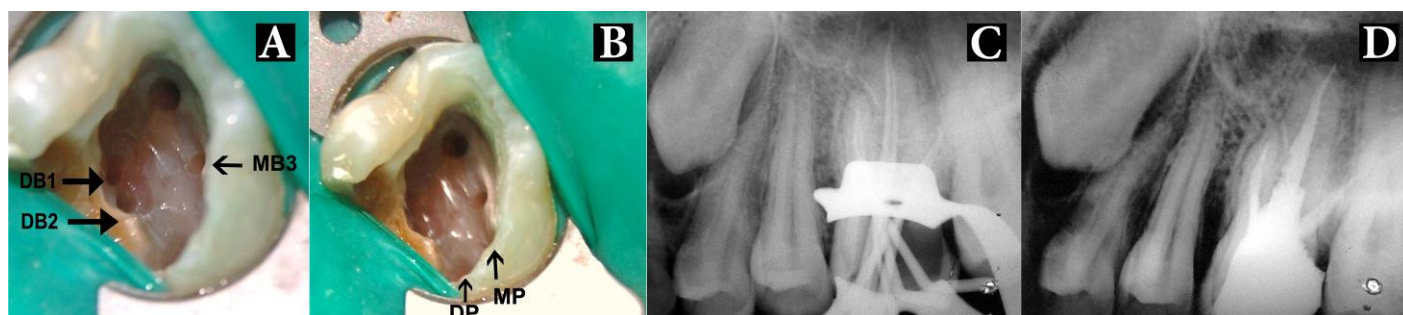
A and B) Access opening showing the seven root canal orifices; C) Master cone radiograph in eccentric angulation; D) Final radiograph
